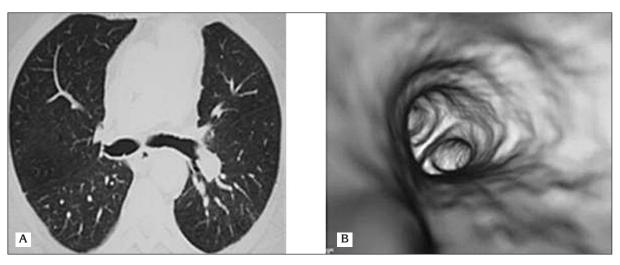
There was no evidence of recurrence at (A) chest CT and (B) virtual bronchoscopy.
